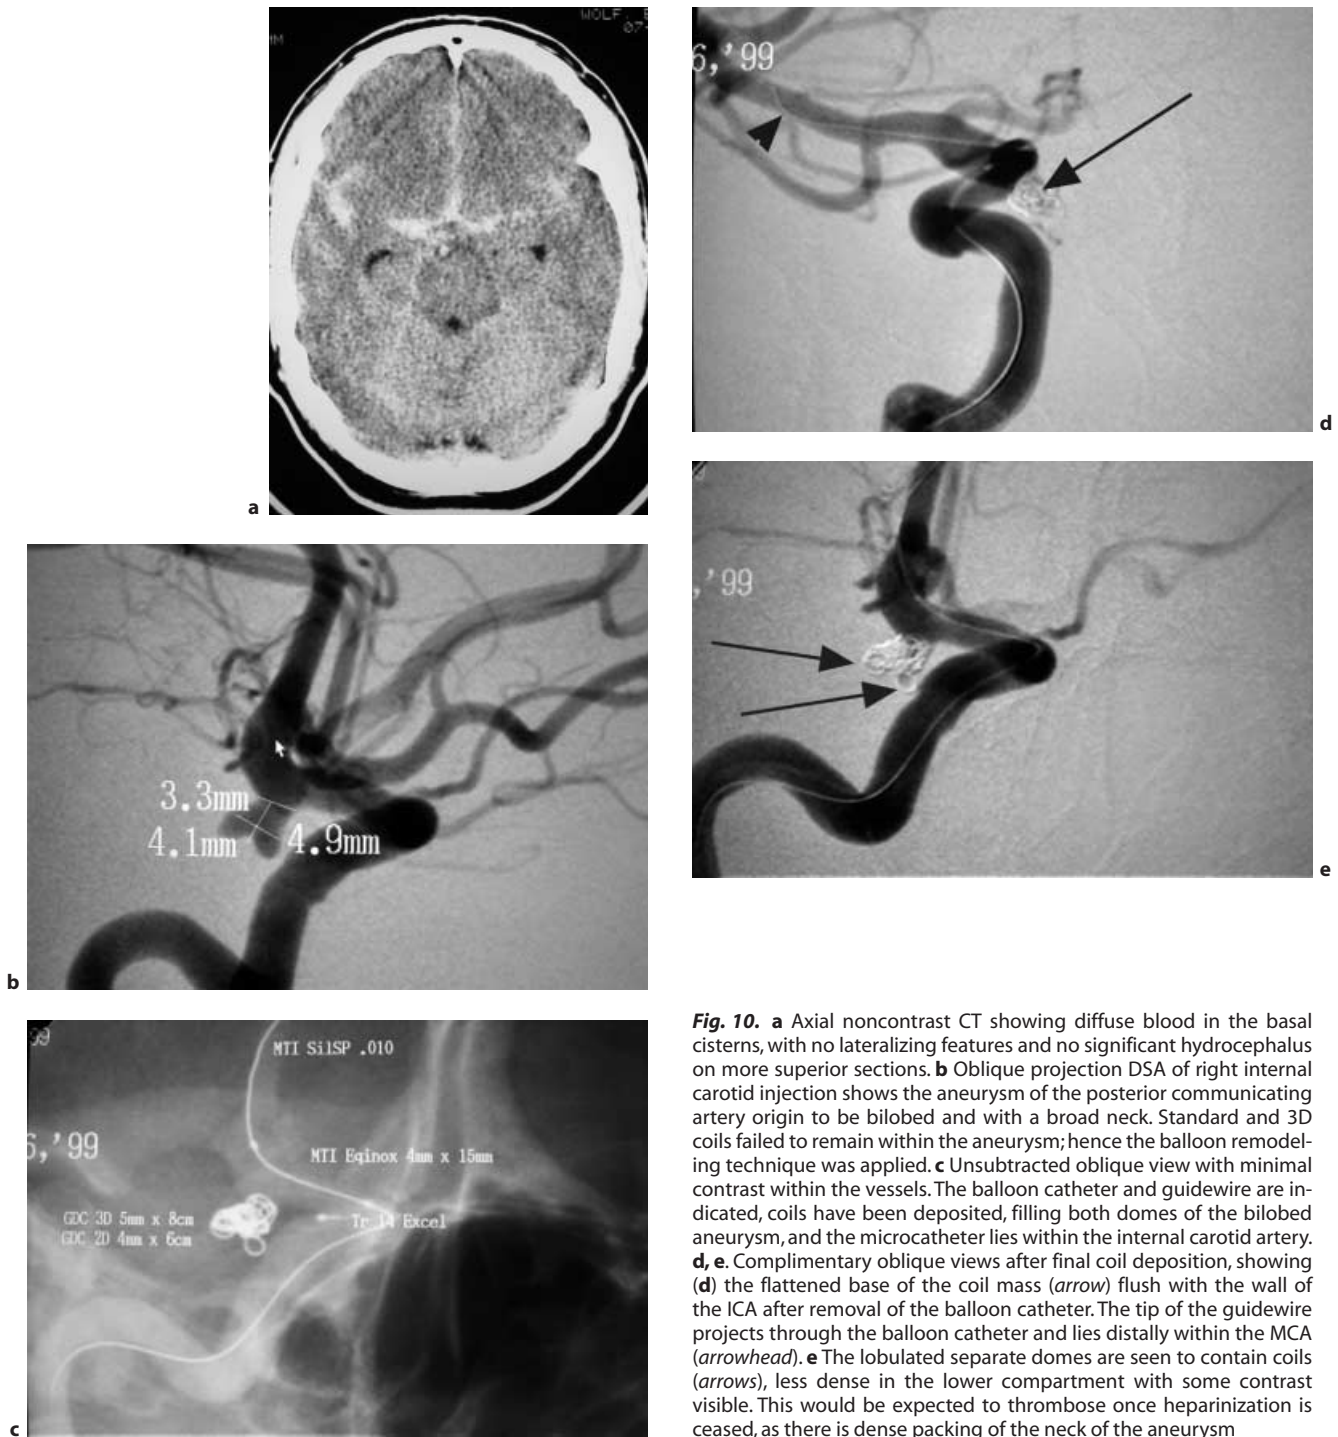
a Axial noncontrast CT showing diffuse blood in the basal cisterns, with no lateralizing features and no significant hydrocephalus on more superior sections. b Oblique projection DSA of right internal carotid injection shows the aneurysm of the posterior communicating artery origin to be bilobed and with a broad neck. Standard and 3D coils failed to remain within the aneurysm; hence the balloon remodeling technique was applied. c Unsubtracted oblique view with minimal contrast within the vessels. The balloon catheter and guidewire are indicated, coils have been deposited, filling both domes of the bilobed aneurysm, and the microcatheter lies within the internal carotid artery. d, e. Complementary oblique views after final coil deposition, showing (d) the flattened base of the coil mass (arrow) flush with the wall of the ICA after removal of the balloon catheter. The tip of the guidewire projects through the balloon catheter and lies distally within the MCA (arrowhead). e The lobulated separate domes are seen to contain coils (arrows), less dense in the lower compartment with some contrast visible. This would be expected to thrombose once heparinization is ceased, as there is dense packing of the neck of the aneurysm
